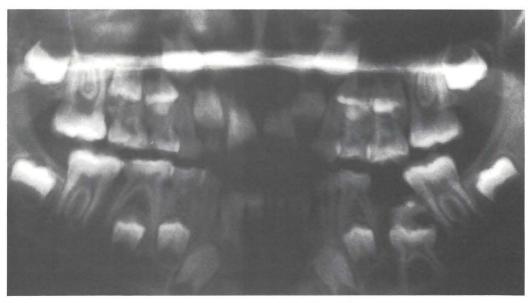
The orthopantomogram taken at the age of eight shows the unerupted primary left mandibular second molar. The developing second premolar is positioned occlusally to the crown of the unerupted primary tooth.
